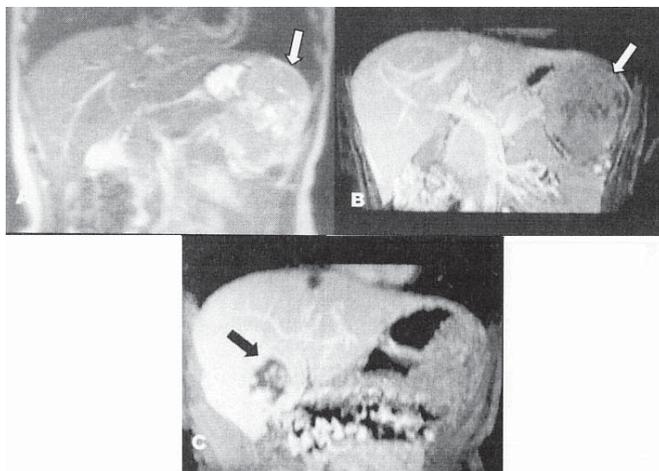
Large gastric stromal tumor (white arrows) on coronal T2-weighted magnetic resonance imaging sequence (A) and coronal post-contrast volumetric reconstruction (B). A hepatic hemangioma is observed in (C) (black arrow)
